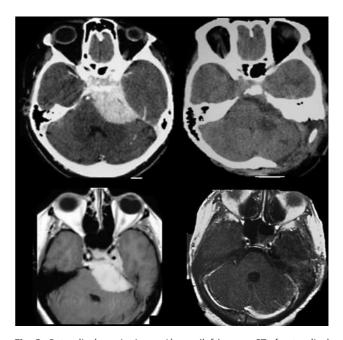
Petroclival meningioma. Above: (left) preop CT of petroclival meningioma; (right) postop CT, note the mastoidectomy of the posterior petrosal approach. Below: (left) preop MRI of the case, (right) postop MRI presenting extensive removal. CT, computed tomography; MRI, magnetic resonance imaging.
